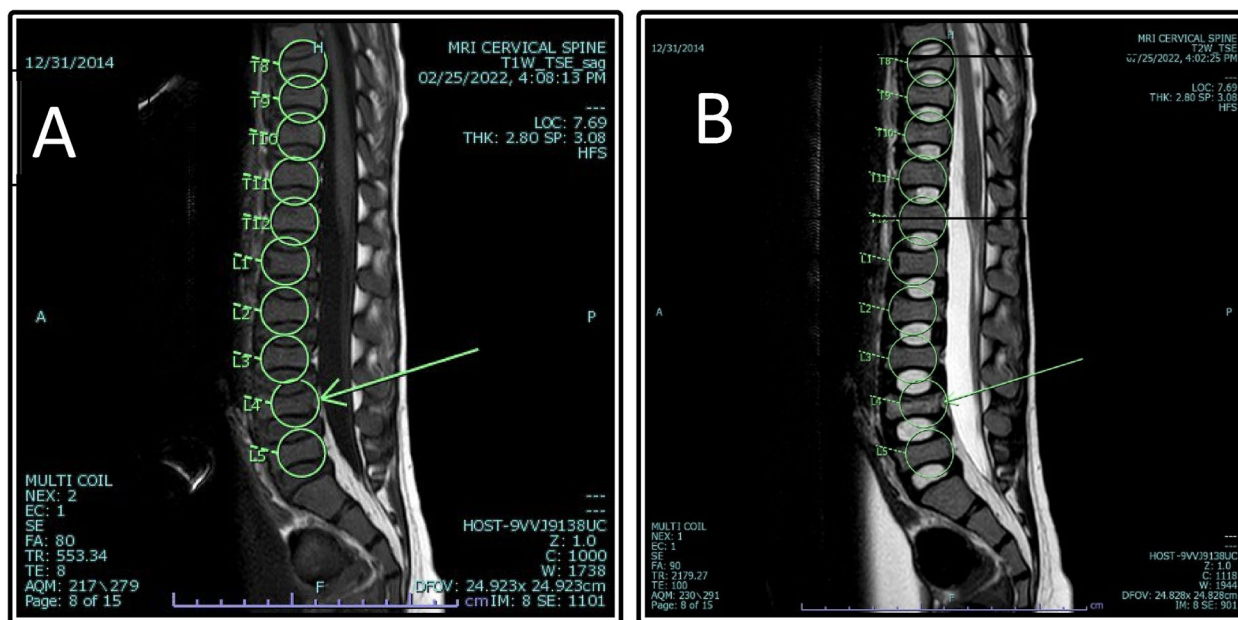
MRI lumbar showing compression fracture at L4. A T1W. B T2W*
